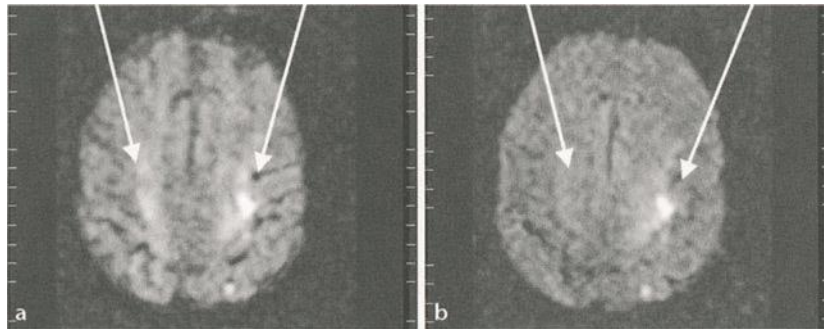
Anisotropic (a) and isotropic DWI (b). There is a definite lesion in the left parietal lobe of the MCA territory seen on both DWI (arrows). The lesion in the right parietal lobe seen in a is physiological diffusion in the corona radiata which cannot be depicted anymore in b (arrows).
